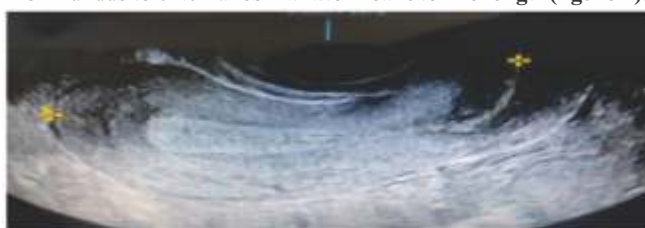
mid saggital plane of the uterus on B mode ultrasound measuring anatomical uterine length
